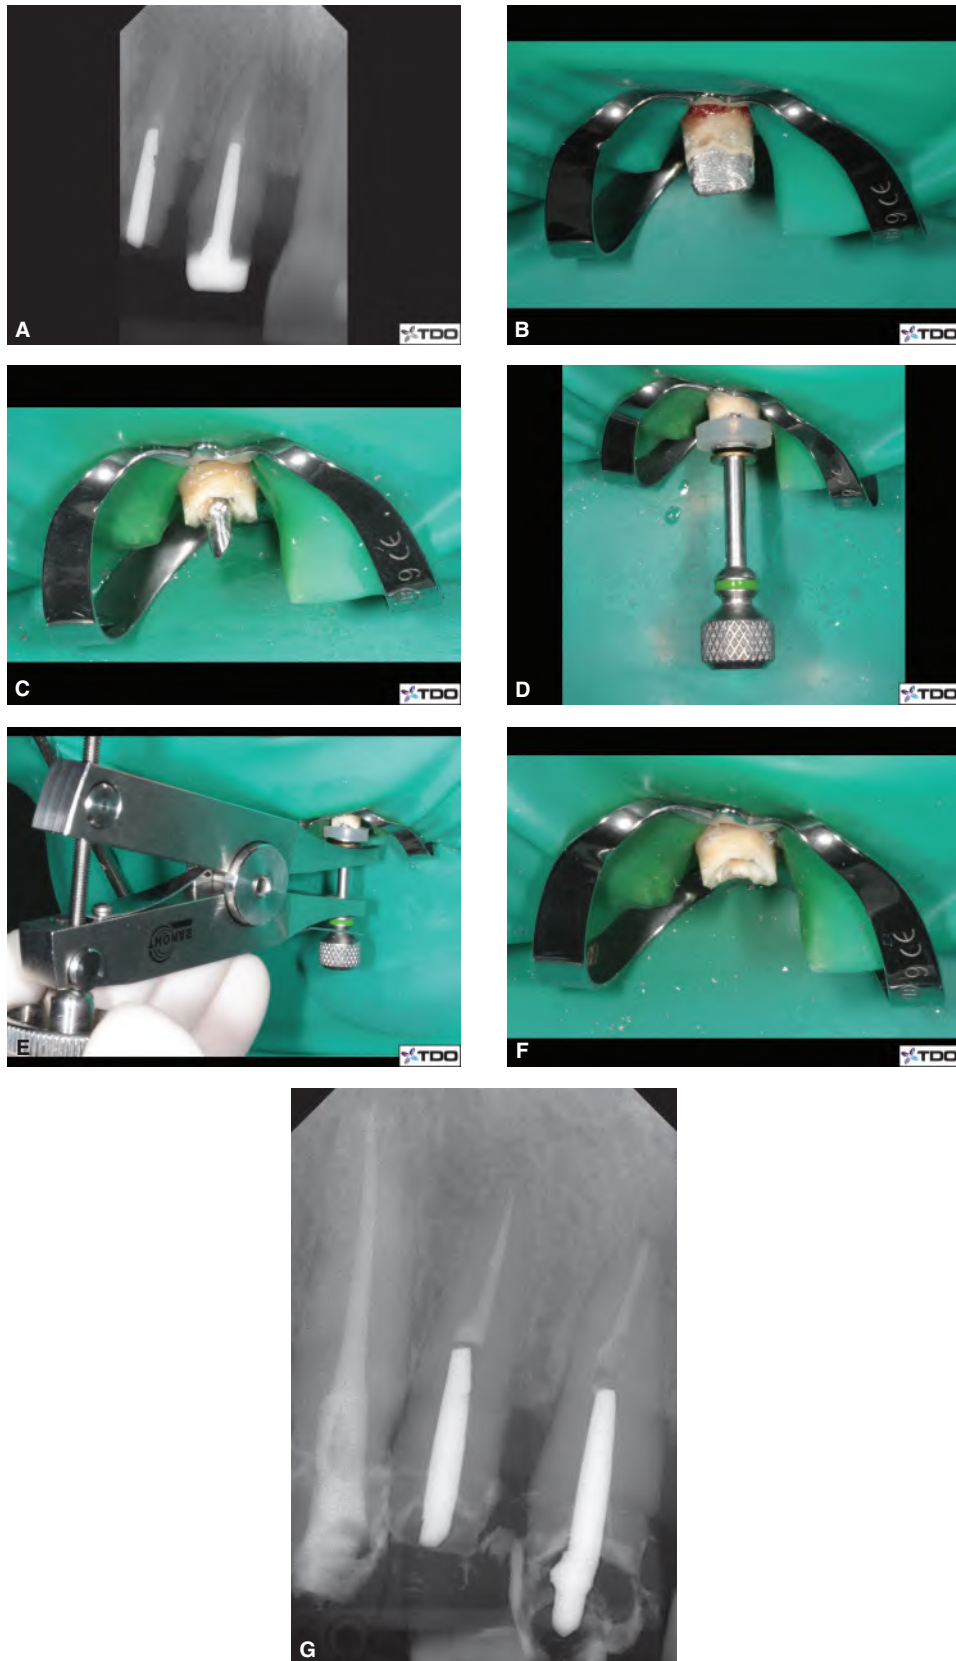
A.* Two metallic posts must be removed before retreatment. *B.* Clinical view of the metallic core. *C.* Circumferential pre-reduction of the core before tapering the head of the post to facilitate the centering of the trephine. *D.* The tubular tap with the three washers creates a threading on the post. *E.* The pliers are connected to the tubular tap. *F.* Post removed from the root. *G.* Postoperative radiograph of the teeth after retreatment and placement of provisional restorations.
